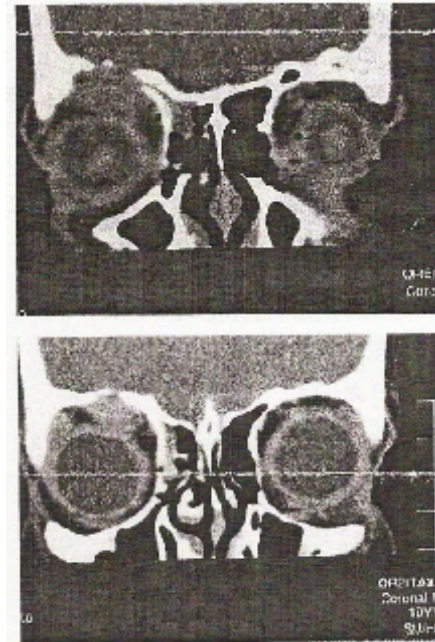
CT of the orbits depicting a tumor in the superior right orbit and a lytic lesion of right orbital roof with tumor extension into frontal sinus and anterior cranial fossa.
